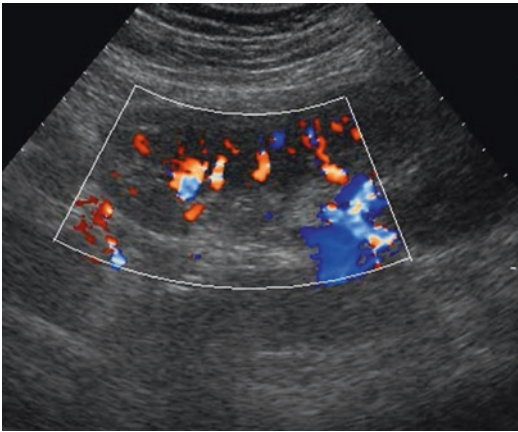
Pre-biopsy evaluation. It is essential to evaluate renal vasculature with color Doppler to identify the presence of an abnormal vascularization
